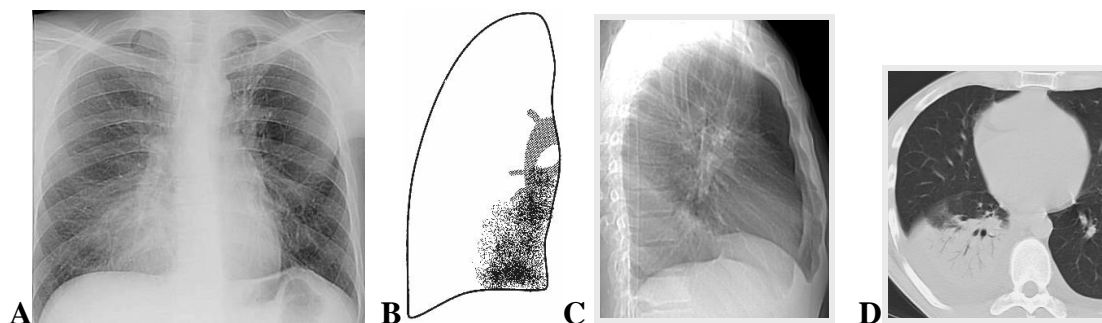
(A) Frontal CRX, (B) scheme to (A), (C) lateral CXR and (D) axial CT tomogram shows a focal shadow in the right lower lobe. There is opacification within the lower zone of the right lung field. In the given example there is loss of definition of the right heart border. From this you can work out where the consolidation is located. The right middle lobe (which is normally air filled) is adjacent to the right atrium. This is why you normally see the margin of the right atrium. The consolidation within the right middle lobe causes loss of the air/soft tissue interface and hence loss of definition of the border
